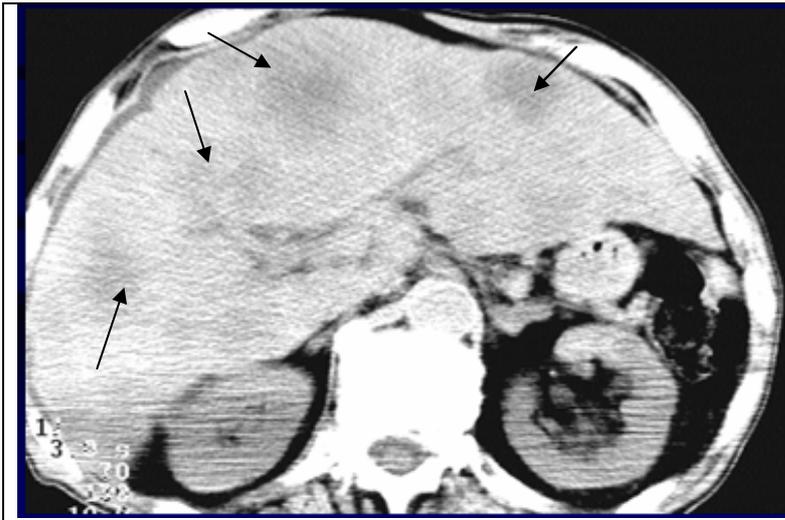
CT at metastasises reveals spherical or irregular-shaped areas of low density against the background of parenchyma.
